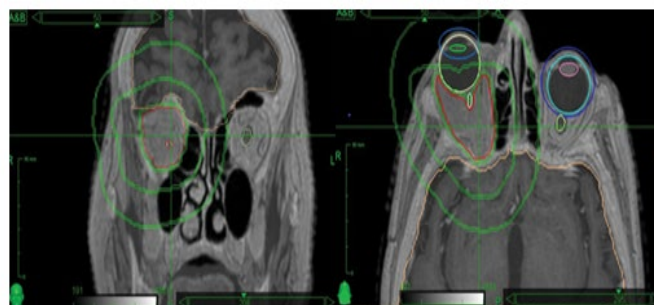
Images of pre-treatment CT/MRI.
